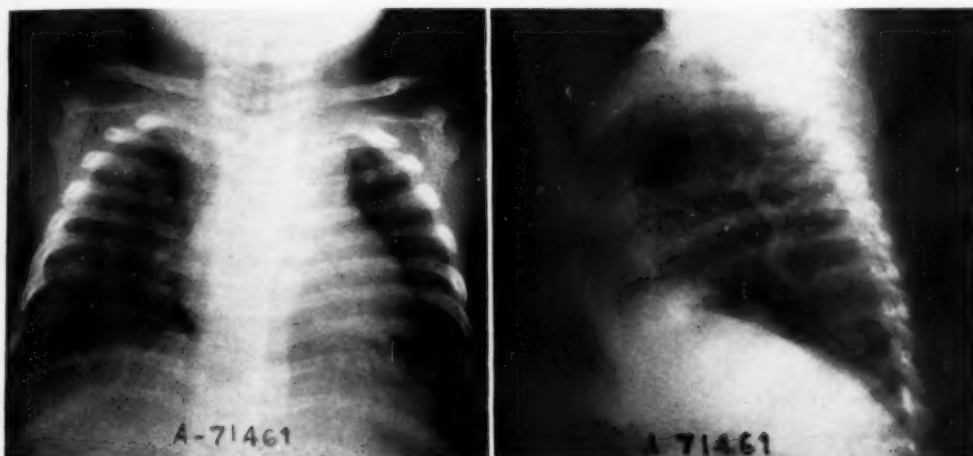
Case I: Chest roentgenograms at eleven weeks of age, showing slight irregularity of aeration of the lungs, mild generalized emphysema with increased anteroposterior diameter of the chest, and narrowing of the tracheal lumen (seen on the lateral film) in the upper intrathoracic region.
